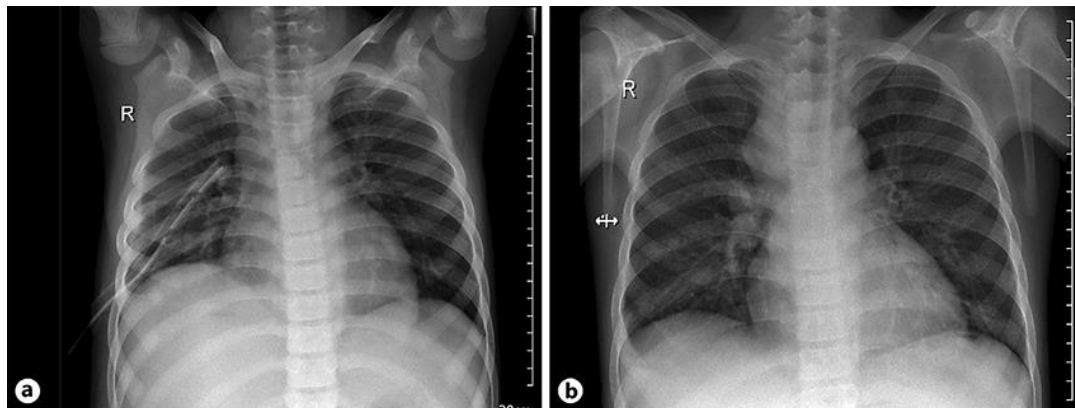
a First follow-up chest radiograph after PD suspension and HD initiation showed reduction of pleural effusion. b The 3-year follow-up chest radiograph showed complete resolution of pleural effusion with no recurrence.
